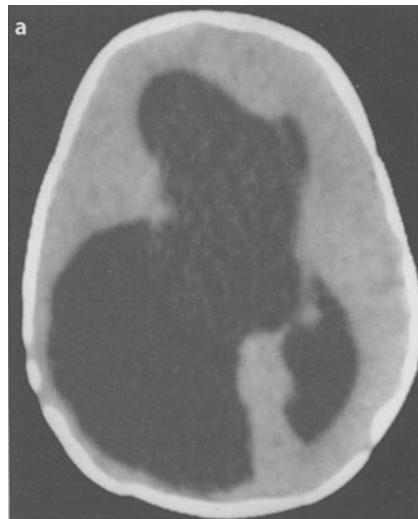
A 4-month-old girl. a Axial CT scan, b coronal T₁-weighted MRI (3D GRASS). Both images show dilatation of the right ventricle secondary to unilateral atresia of the foramen of Monro. c Same patient after endoscopic septostomy. CT scan with lumbar injection of contrast medium. Both ventricles have opacified, the left better than the right. Note the unopacified subdural collection
